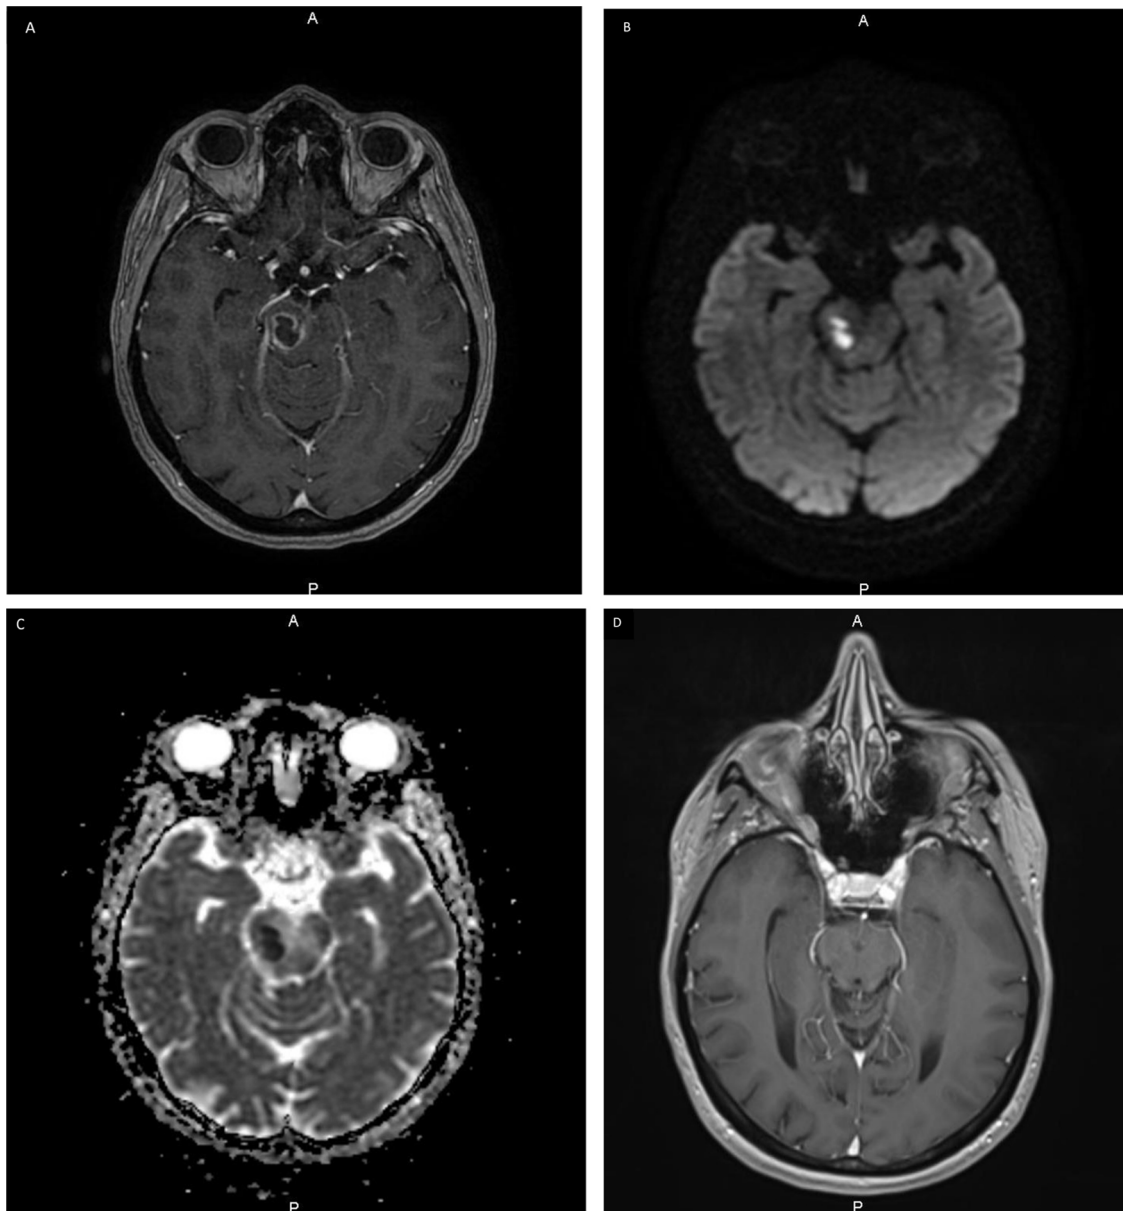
MRI shows a brainstem lesion. (A) Axial post-contrast T1-weighted MR image shows a right midbrain lesion with circumferential enhancement. (B) Axial diffusion MR image shows a high-signal-intensity area. (C) Axial diffusion with apparent diffusion coefficient (ADC) MR image shows a low-signal-intensity area. (D) Axial post-contrast T1-weighted MR image after 6 months showing a small residual hypointense sequela of the midbrain without contrast enhancement that correlated with the effectiveness of the antibiotic treatment.
